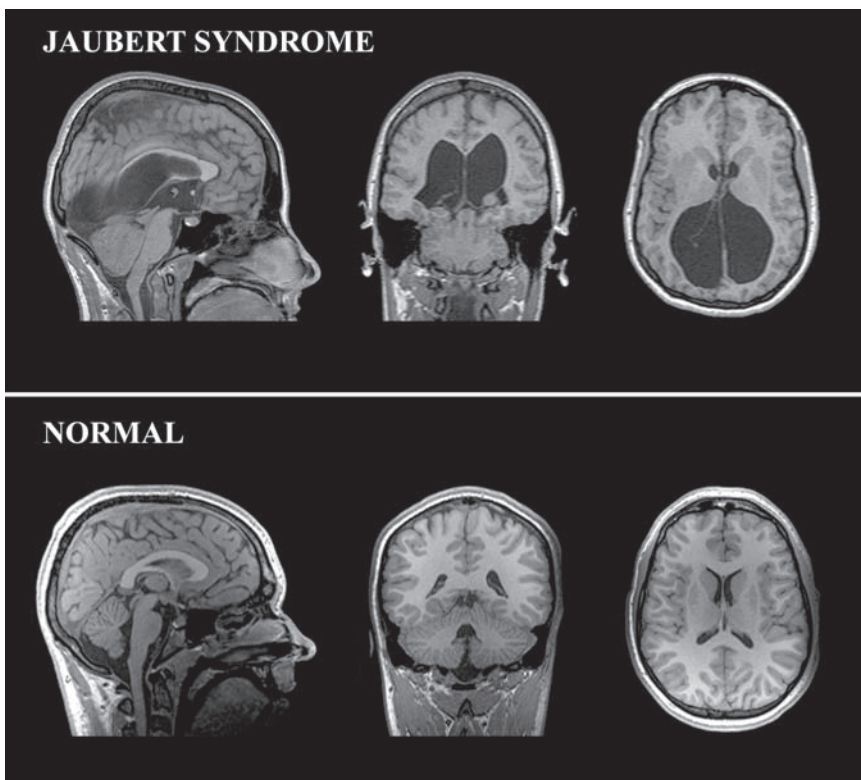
T2-weighted image of a young female with Jaubert syndrome resulting in the development of an occipital encephalocele, which was surgically removed at birth (top). Compared to the image from a typically developing young adult (bottom), note the enlarged ventricles, thinning of the corpus callosum, and underdeveloped cerebellar vermis.
